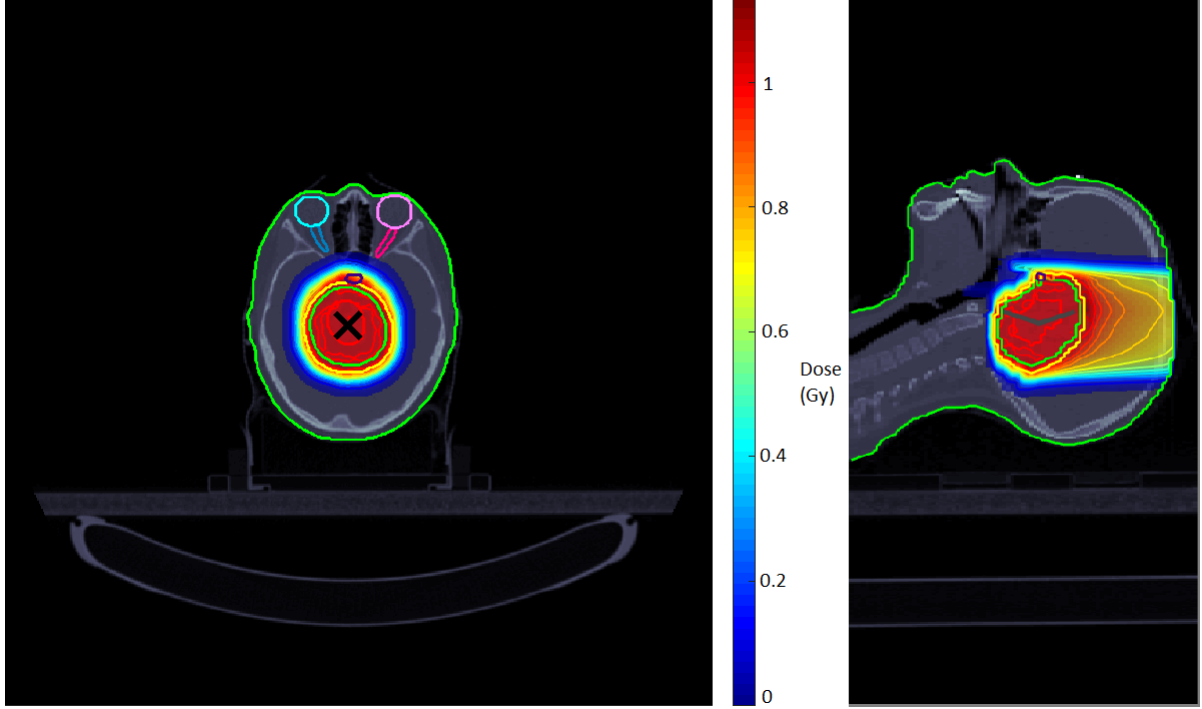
Axial (left) and sagittal (right) views of the CT with the dose delivered through matRad optimization. No dose is delivered to either eye or optical nerve.
